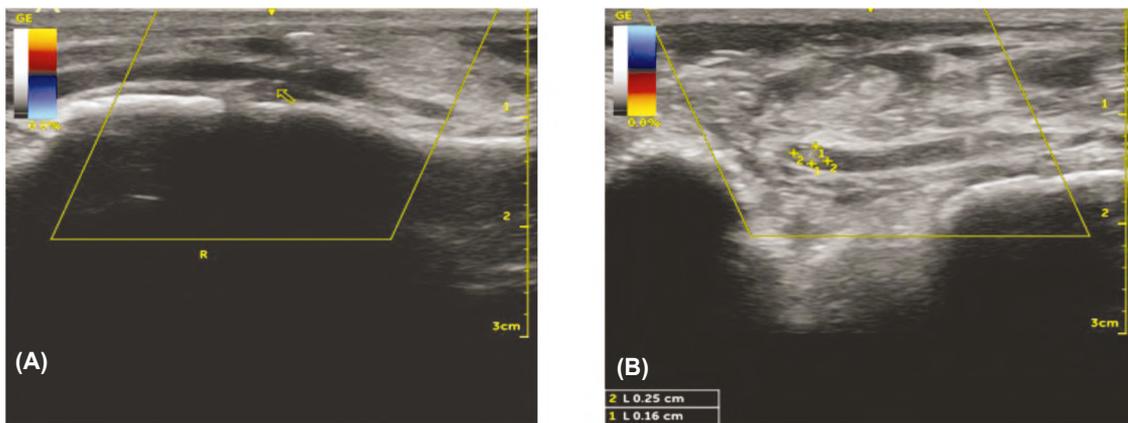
36 years old male patient came to ER after road traffic accident ultrasound image shows vascular abnormalities on ultrasonography: Decreased arterial diameter and blood flow (A); partial arterial or venous disruption, partial arterial thrombosis (B).
